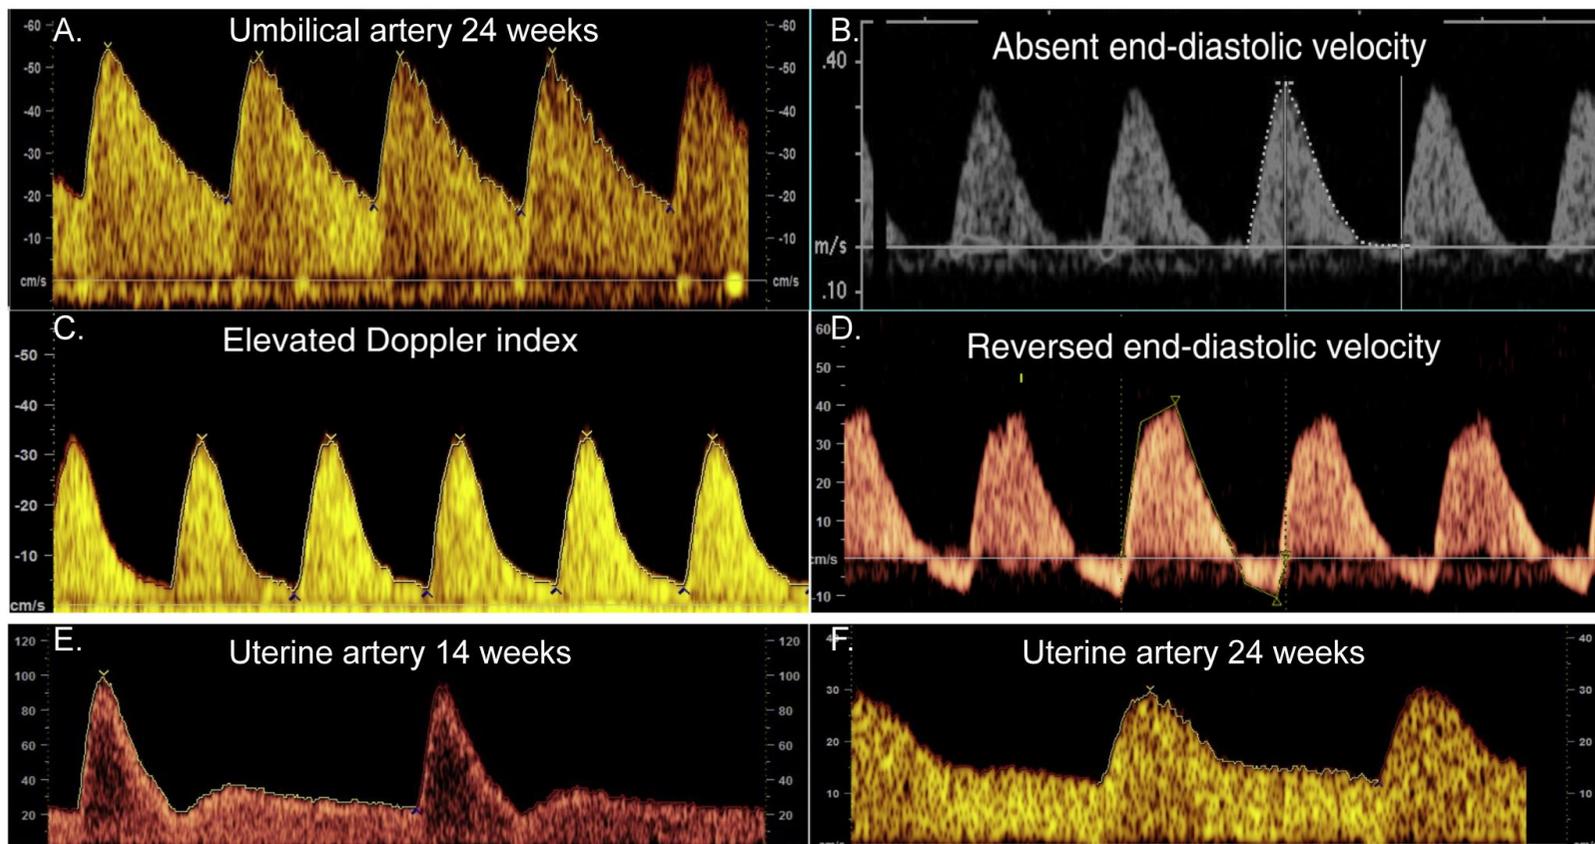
Umbilical (UmA) and uterine artery (UtA) Doppler waveforms in normal pregnancy and pregnancy complications
